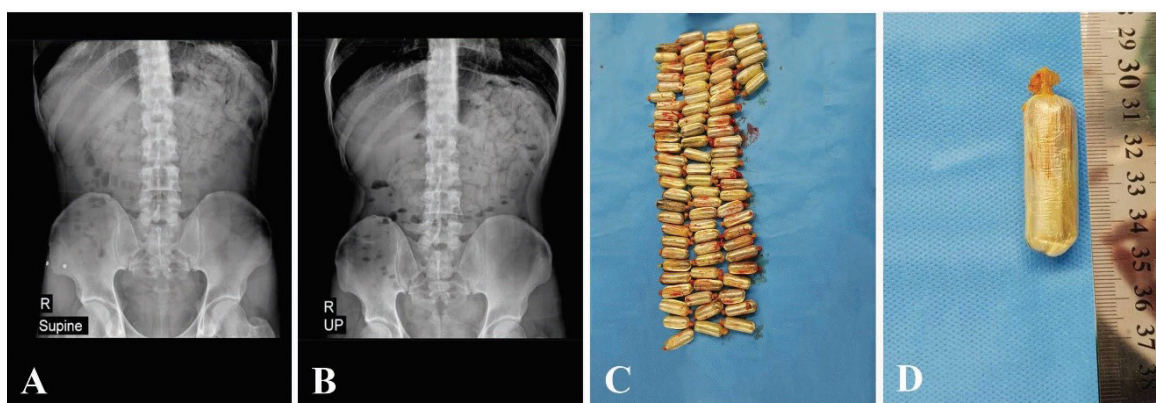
Abdominal supine (A) and upright (B) plain X-ray of the patient. The packs removed from patient's stomach (C and D)
